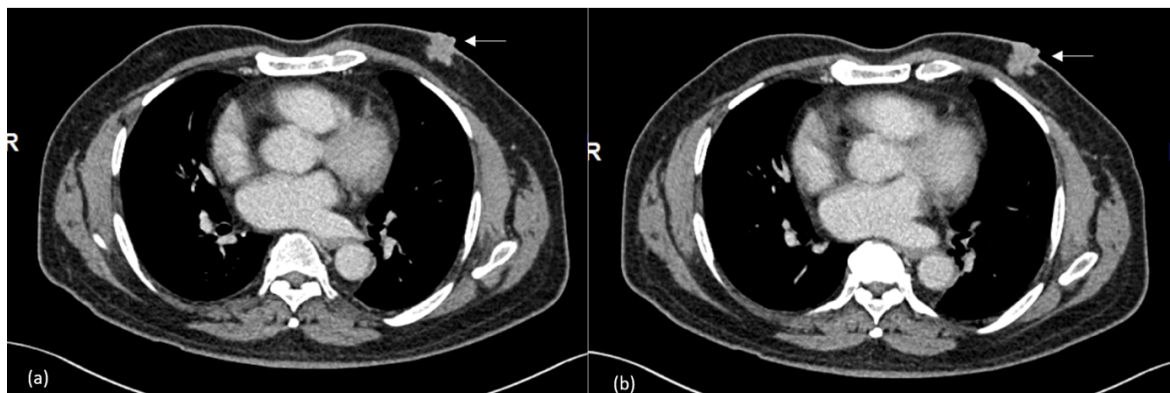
Serial contrasted CT images of enhancing spiculated left retro-areolar soft tissue lesion
